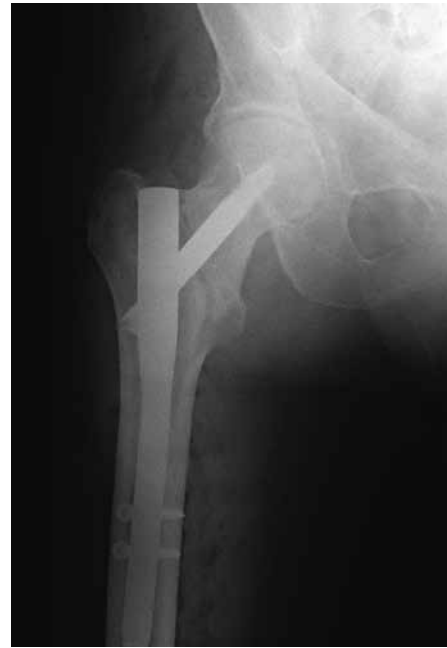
Post-operative anteroposterior radiograph of the same patient treated with DLT nail.
